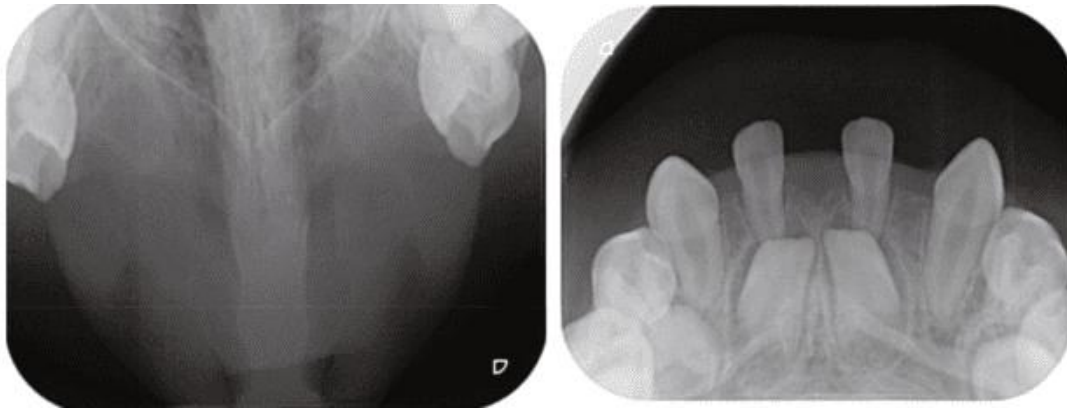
Occlusal view radiography of both the maxillary and the mandibular of the nonsyndromic oligodontia patient [20].
